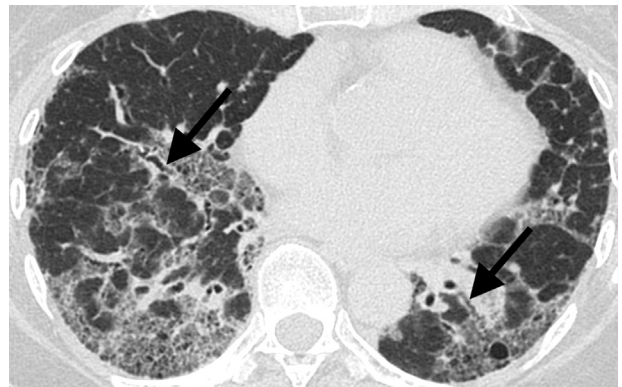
Nitrofurantoin toxicity. Axial CT in chronic toxicity shows an NSIP pattern with bilateral reticular opacities with few areas of bronchiolectasis (arrows) without honeycombing.
